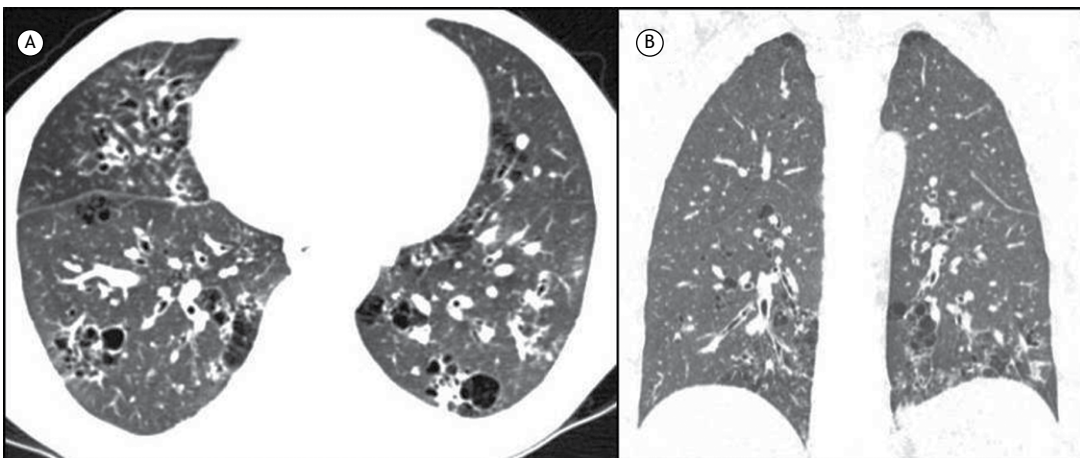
CT scans of a 33-year-old male patient who had been HIV-positive for three years and was poorly compliant with treatment. He had dyspnea and lung involvement secondary to pneumocystosis. In A, axial reconstruction demonstrating diffuse areas of ground-glass density, interspersed with bronchial wall thickening and several peribronchovascular cystic structures of various sizes. In B, coronal reconstruction showing lung cysts with a peribronchovascular distribution.
